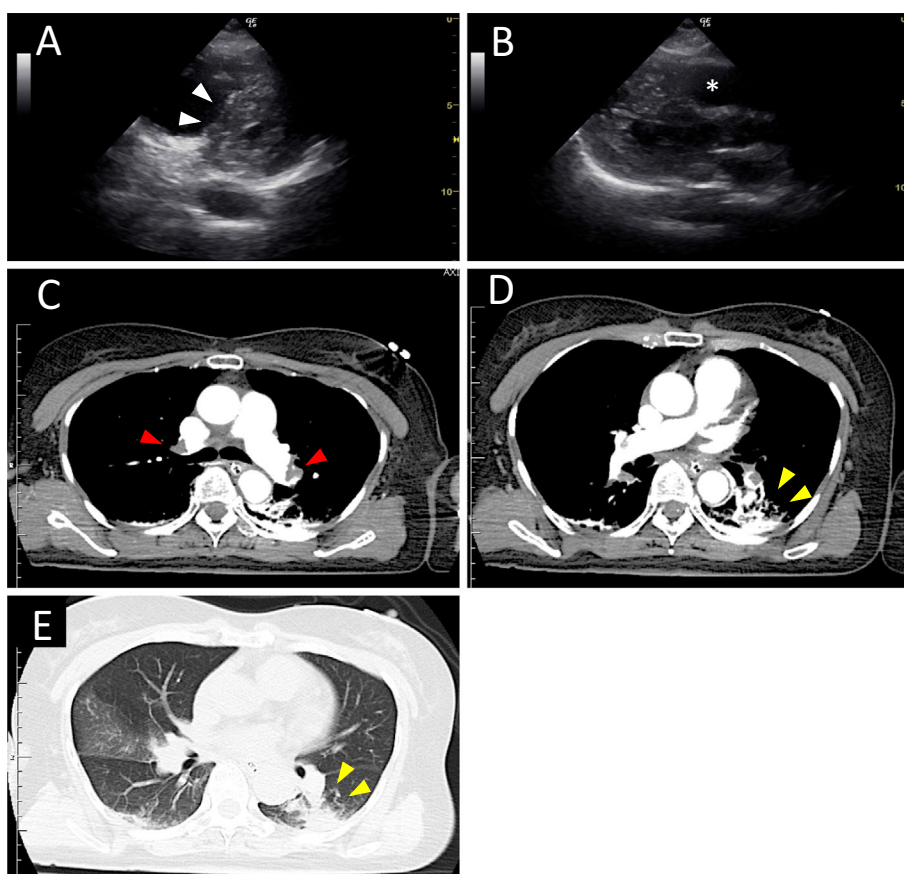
Echocardiography and contrast-enhanced CT images obtained at admission to the hospital (A, B). The right ventricle was significantly dilated (asterisk), resulting in flattening of the interventricular septum (arrows). (C, D, E) Emergency CT showed a thrombus in the bilateral pulmonary artery (red arrows) as well as parenchymal infarction in the left lower lobe (yellow arrows). CT: computed tomography
